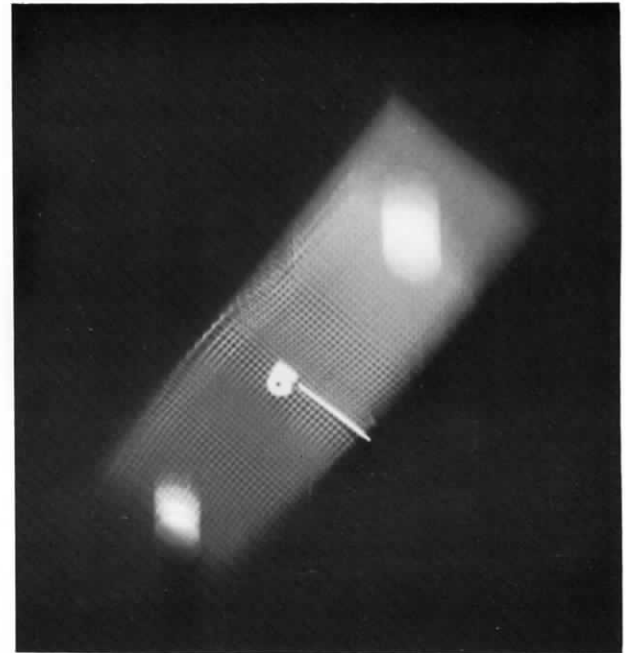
Erratic motion of the tomographic unit will produce several areas that appear to be sharp at different levels with blurred areas in between. In addition, you can easily see multiple images of the tacks holding the screen, indicating that the x-ray tube was not moving smoothly.
